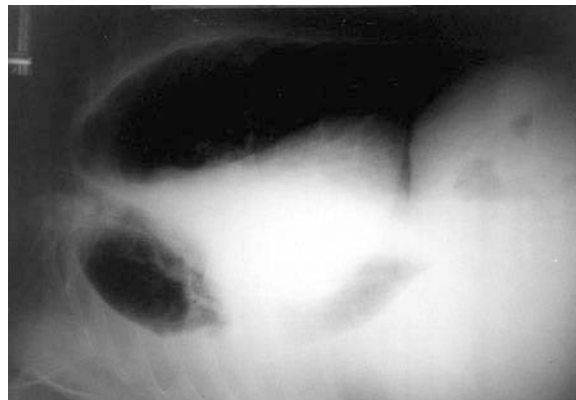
Lateral decubitus chest radiograph.
